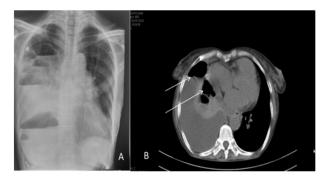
A: X-Ray chest PA view showing multiple air fluid levels on the right side. 1 B: CT scan thorax showing right pleural effusion. White arrows points to air fluid levels in the pleura and parenchyma.
